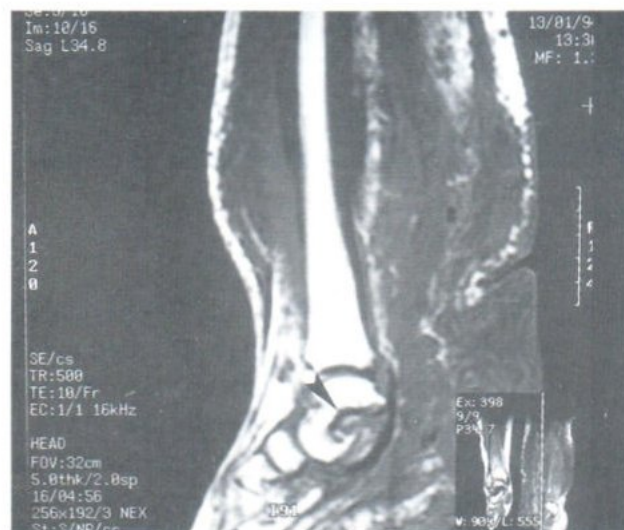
T1- weighted (500/10 [TR/TE]) sagittal MR image reveals an infiltrating soft tissue PN showing lower-than-muscle SI and causing bone erosion of the tarsal bones (black arrowhead).
